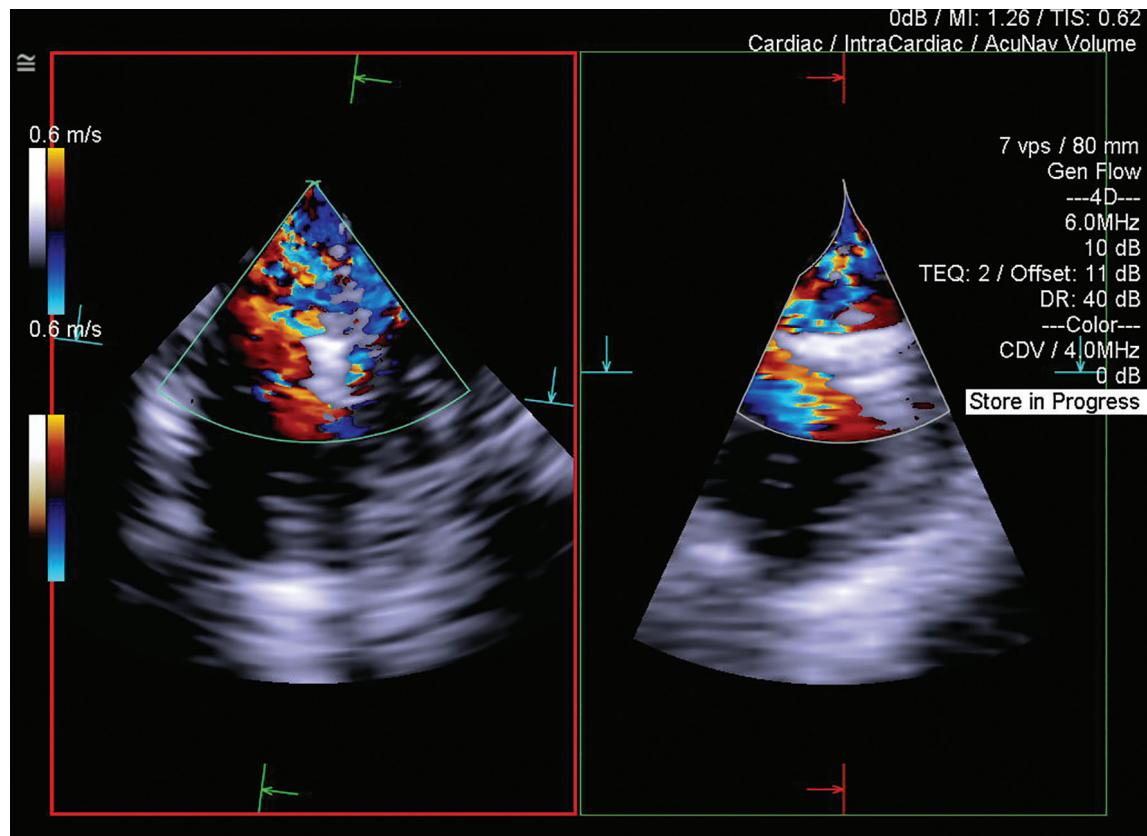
Biplane imaging with and without color Doppler helps guide device to optimal position.
